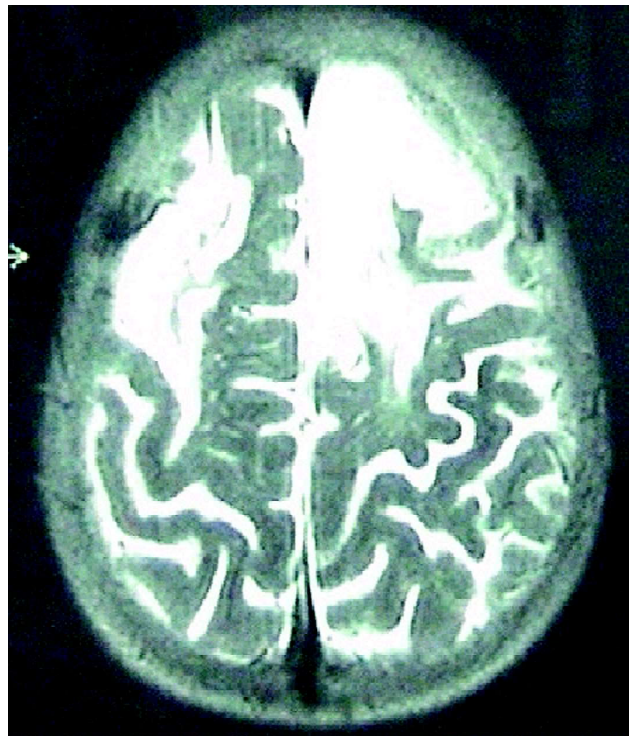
T2 weighted axial MRI image showing bilateral frontal hyperintense areas (left > right) suggestive of old infarcts.
